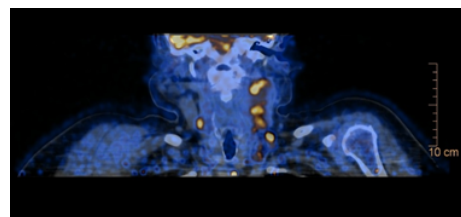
Suspicious lymph nodes more on the left sides on PET/CT
